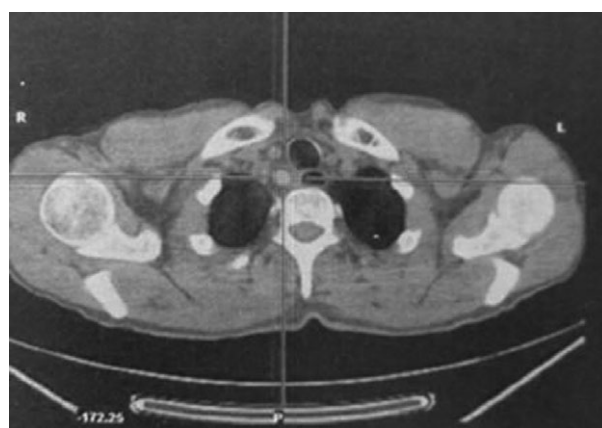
Postoperative supraclavicular lymph node metastasis by positron emission tomography combined with computed tomography.
